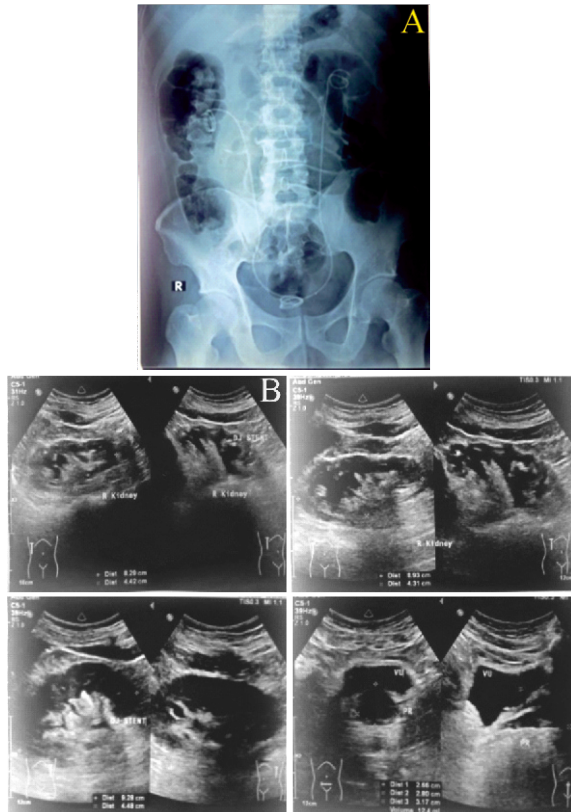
(A) Abdominal X-Ray: No residual stone found, and DJ stent placed on right and left kidney; (B) Urology Ultrasonography: No residual stone on both kidney.
